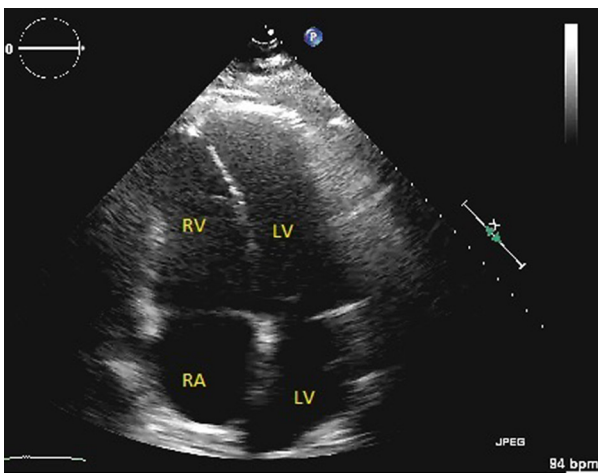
Transthoracic echocardiographic image (apical 4 chamber view) following drainage of the seroma showing resolution of the extrinsic compression of the right heart by the seroma (compare with Fig. 2).
